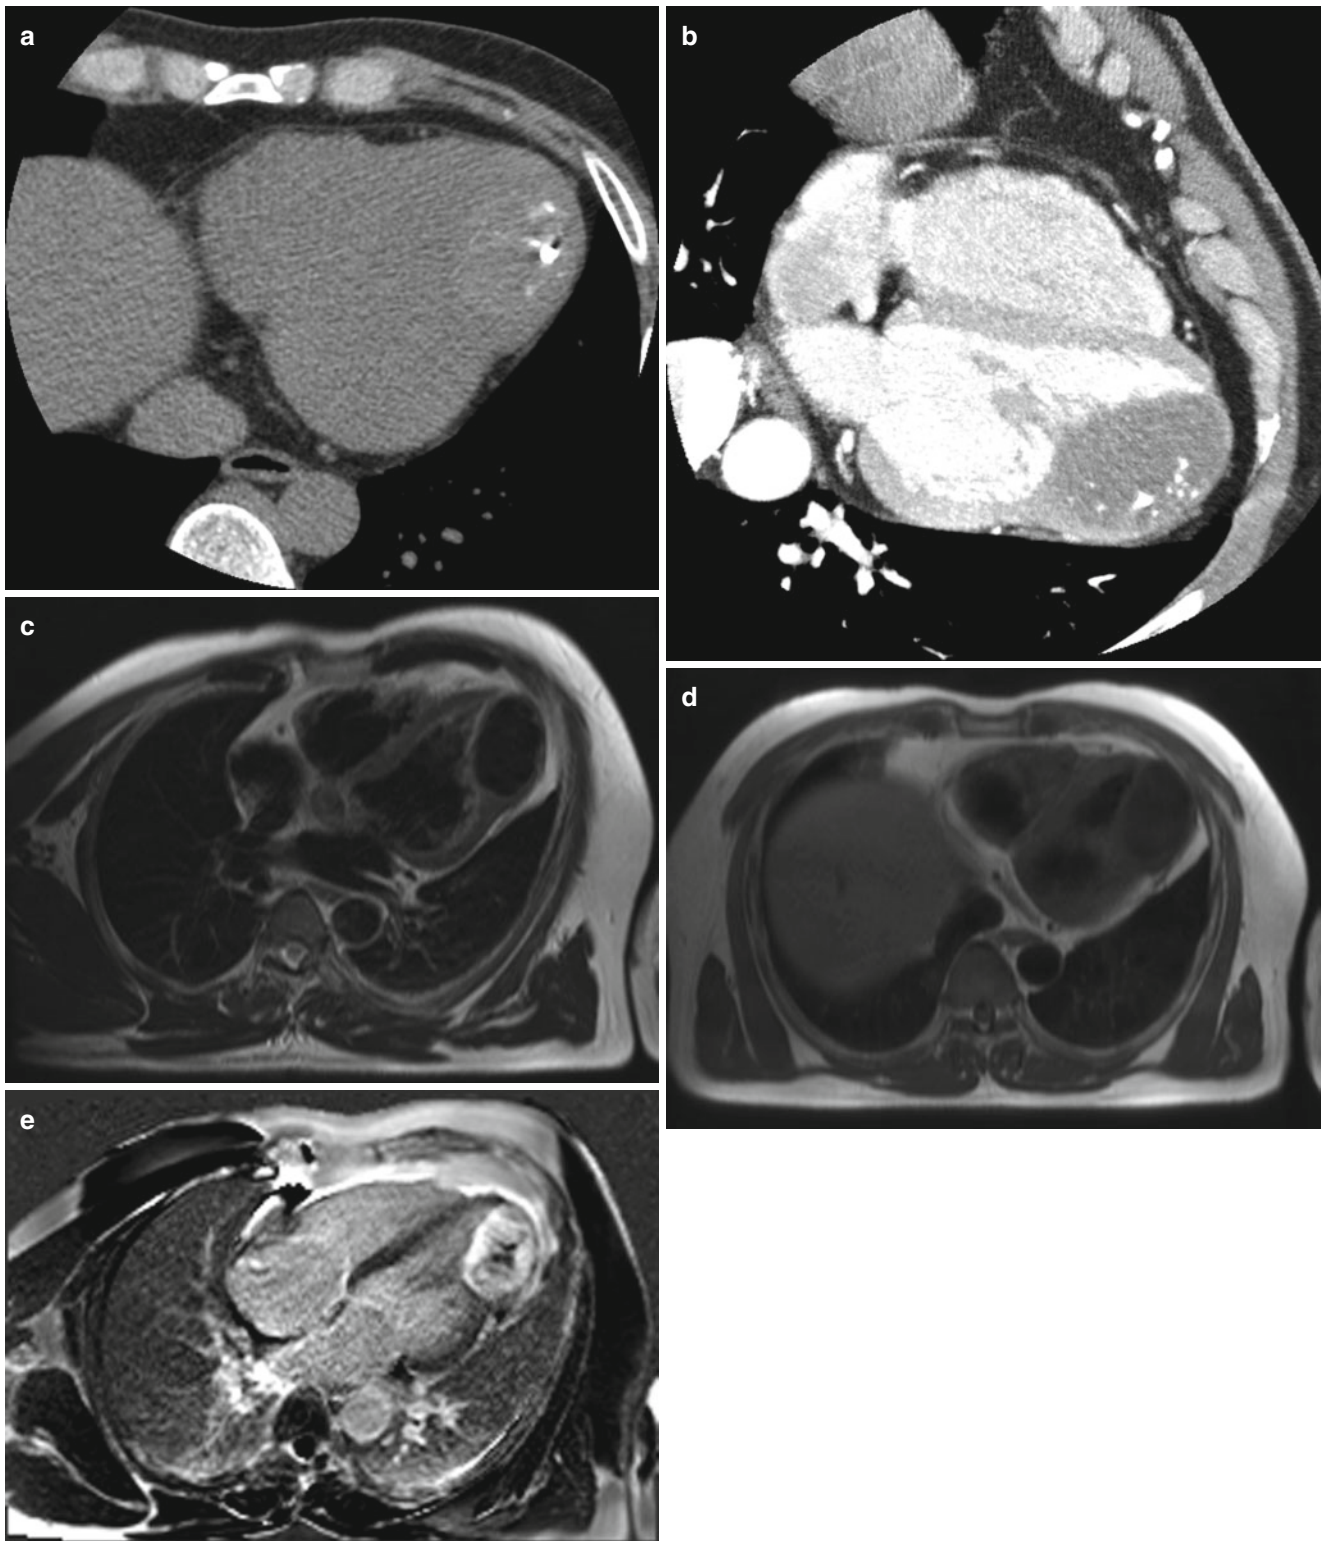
Imaging characteristics of fibroma. (a) A non-contrast CT image shows a mass located at the cardiac apex. The mass is slightly high attenuated with central calcification. (b) In the contrast-enhanced CT image, the mass is not enhanced. (c) In MR T2WI, the mass shows
